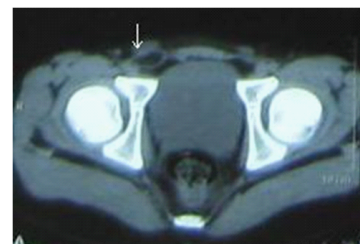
Abdominal CT scan shows right inguinal hernia (arrow head).
